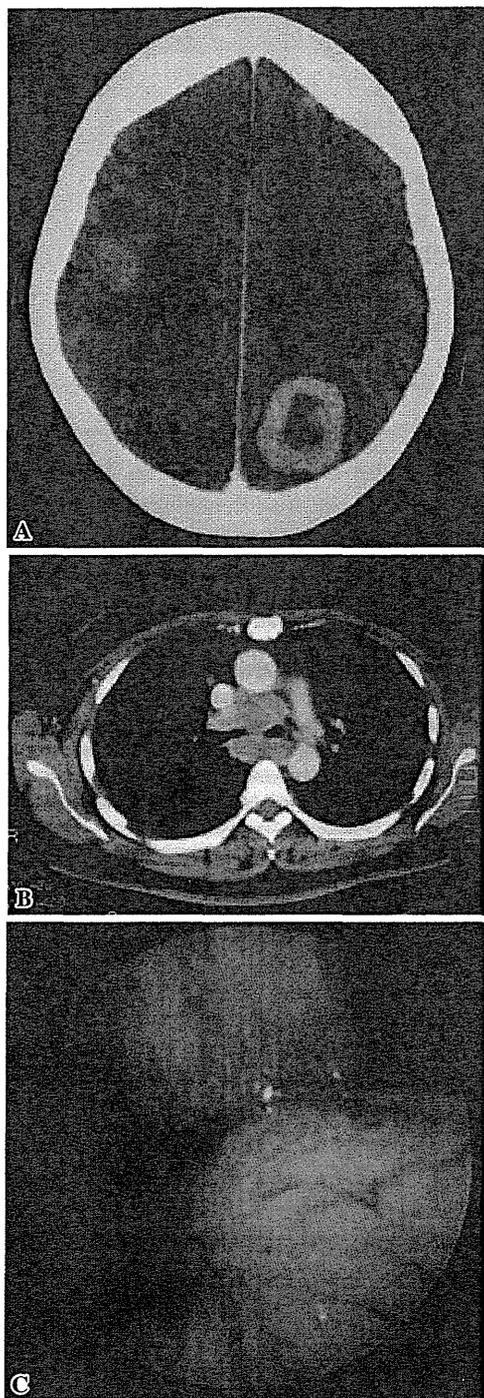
The imaging at presentation. Computed tomography presents multiple brain metastases (A) and mediastinal lymphadenopathy (B). Fiber optic bronchoscopy showed a direct invasion from metastatic lymph nodes to the carina (C). Both bronchi are too narrow to perform further examinations.
